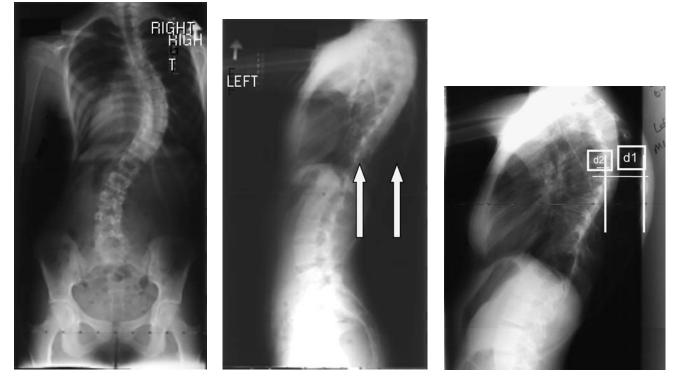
The double-rib contour sign is noted in these standing lateral x-ray films (A) Standing PA x-ray film of a 65-degree scoliosis. (B) Standing lateral x-ray of the same patient. The *arrows* point to the convex and concave ribs (hump) shadows. This identifies the rib hump, and can be compared with scoliometer findings. The length or height of the hump is measured from the posterior vertebral body to
